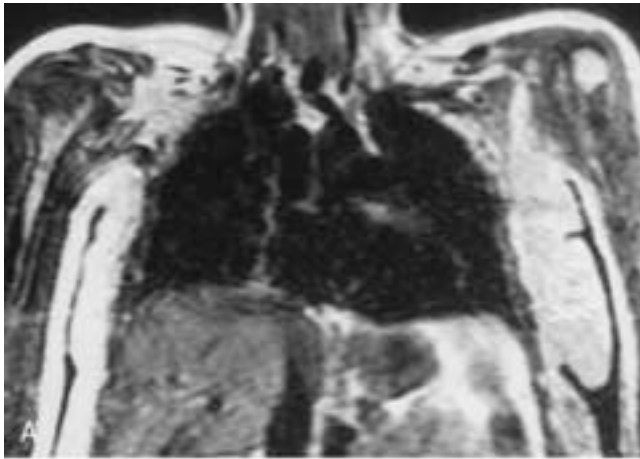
Metastatic breast carcinoma—right humerus. This patient presented with symptoms in the right brachial plexus. Coronal (A) and sagittal (B) T1-weighted MR images demonstrate abnormal marrow signal (absence of high “fat” signal) in the left humeral head. This is consistent with metastatic disease.
